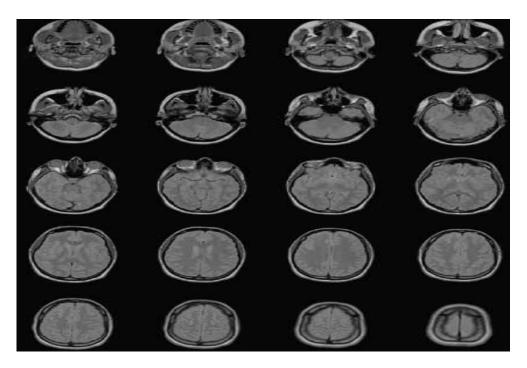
A typical example of the MRI dataset
